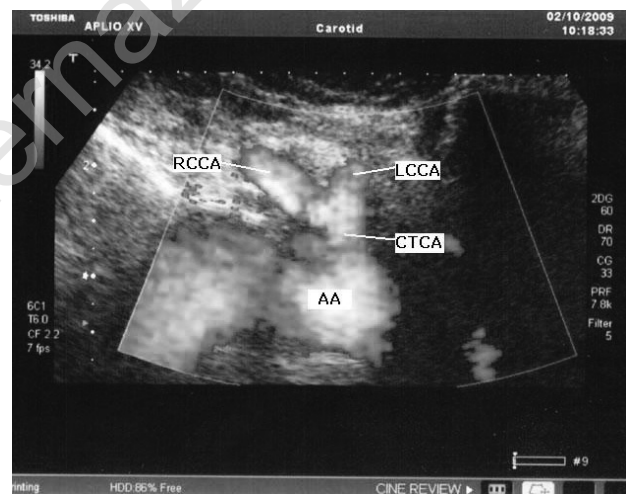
Duplex ultrasound scan. RCCA: right common carotid artery. LCCA: left common carotid artery. CTCA: common trunk of the carotid arteries. AA: aortic arch.
